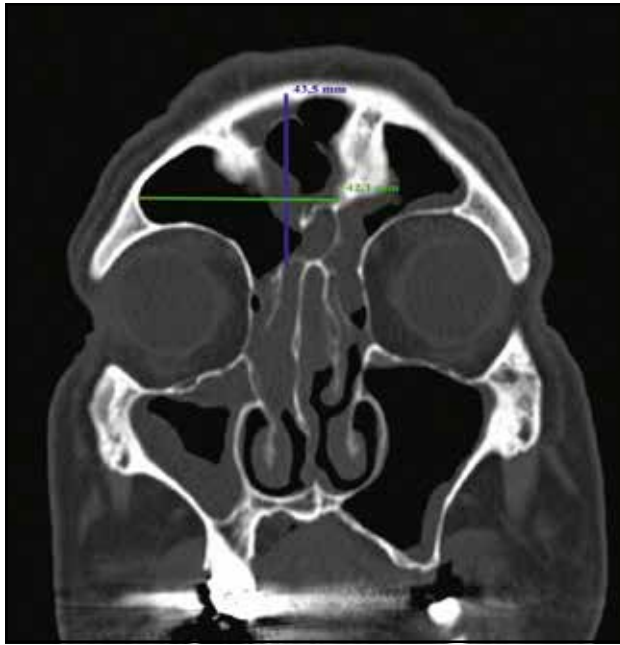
Cranio-facial CT scan A. Coronal view showing pansinusitis and an extensive dilated right frontal sinus – height 43.5mm (blue line), width 42.1mm (green line), with no signs of mucosal or bony injury.
